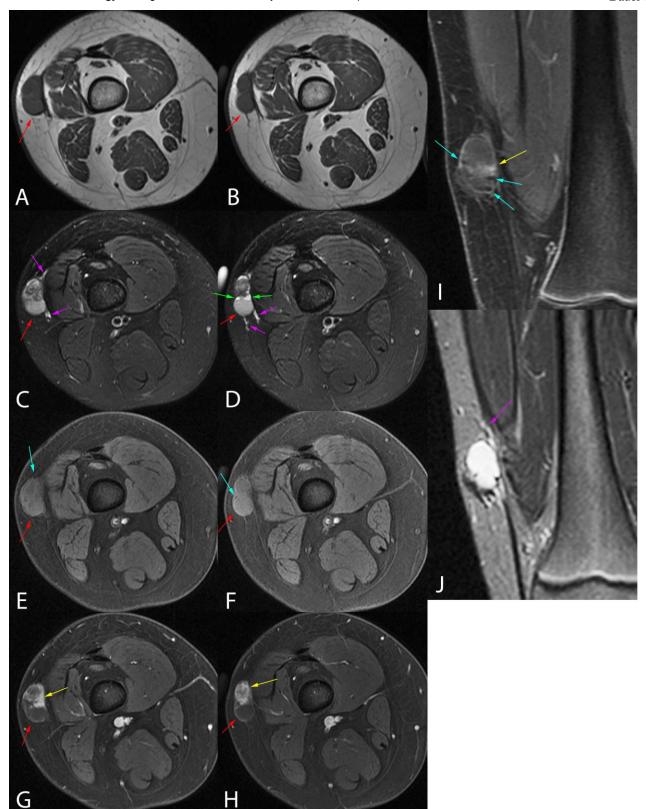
An 11 year-old girl with diagnosis of angiomatoid fibrous histiocytoma. 1.5 Tesla MR scanner axial (A,B) T1-weighted spin echo (TR 617 TE 11.5), (C,D) T2 fat suppressed spin echo (TR 3970, TE 71.3), (E,F) fat suppressed fast multiplanar gradient echo (TR 185, TE 2.27), (G,H,I) axial and coronal fat suppressed fast multiplanar gradient echo (TR 185, TE 2.27) with 16 mL of Magnevist intravenous contrast, (J) coronal STIR (TR 3100, TE 63.14) images. A 1.9 x 3.3 x 3.2 cm well-circumscribed, ovoid, mixed cystic (green arrows) and solid mass is present in the subcutaneous fat of the lateral, distal right thigh abutting the vastus lateralis fascia without evidence of muscle infiltration. The lesion is homogeneously hypointense (isointense to muscle) on the T1WI and heterogeneously hyperintense on the T2WI. The periphery of the mass demonstrates the typical low signal on nonenhanced images representing a fibrous pseudocapsule (red arrows). There is variegated and micronodular peripheral gadolinium enhancement (yellow arrows), as well as nodular peripheral foci of susceptibility artifact on gradient echo images (teal arrows). T2 hyperintensity tracks minimally in the adjacent peritumoral fascial planes representing edema (pink arrows).
